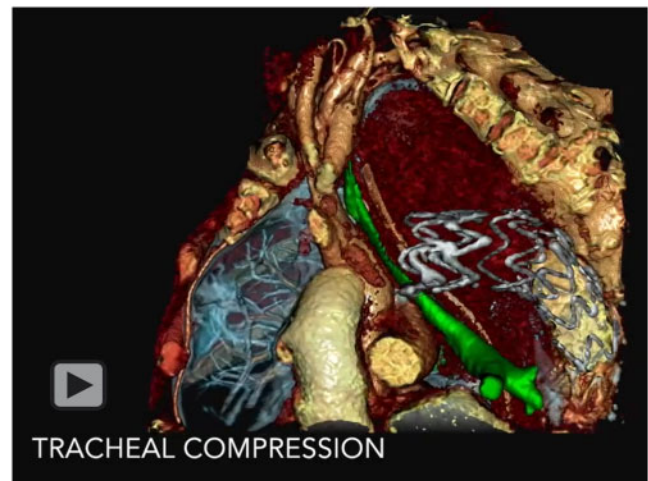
Diagnostic imaging. (A, B) Bronchoscopy revealing a pulsating mass with a variable compression of the tracheal lumen. (C, D) Thoracic computed tomography scan and anatomical 3-dimensional reconstruction demonstrating tracheal (green) compression (\*) by the AS. AS: aneurysmal sac; LMB: left main bronchus; RMB: right main bronchus.
